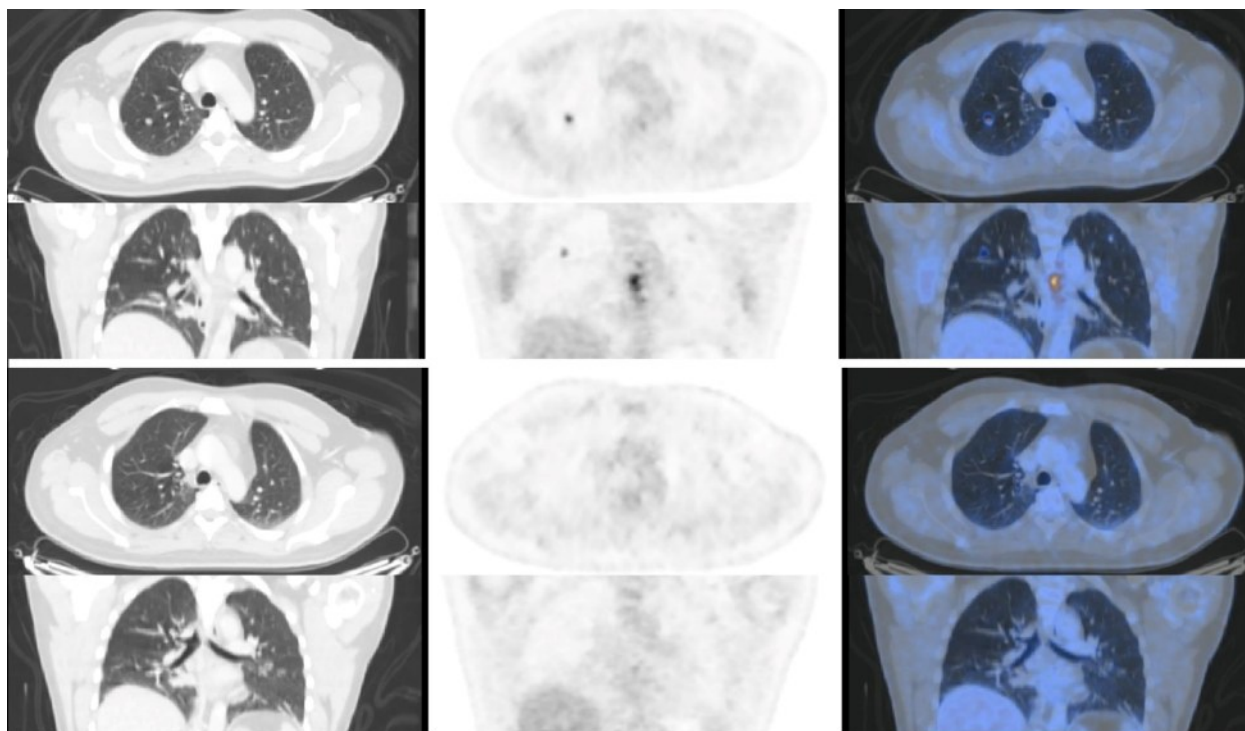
Axial and coronal view showing the (A) CT, (B) PET, and (C) fused PET/CT images of the patient's second whole-body PET/CT scan with emphasis on lung region showing resolution of the pulmonary nodules. Initial PET/CT scan (1st row) and follow-up PET/CT scan (2nd row).
